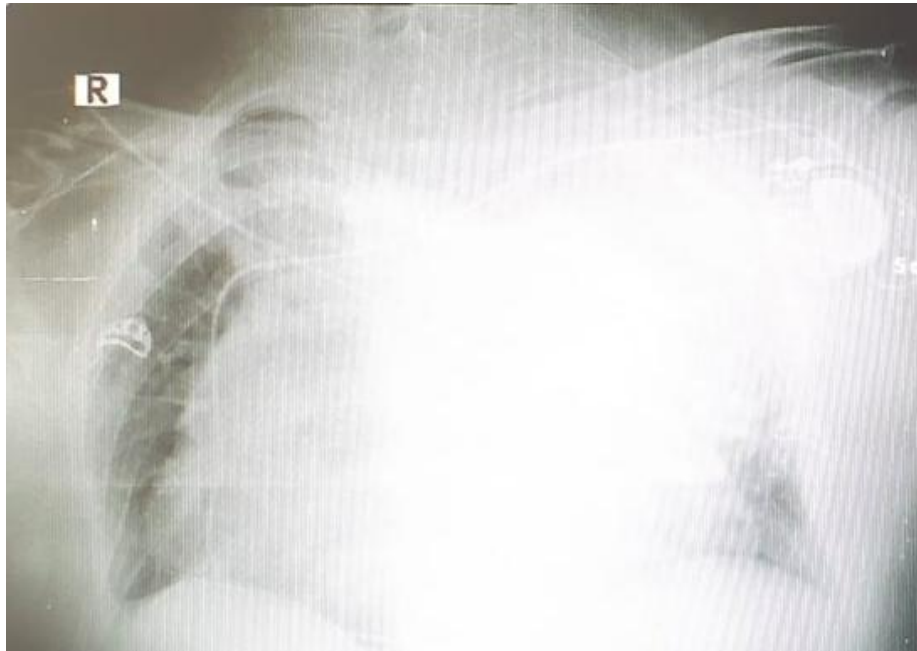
Opacity in the upper and middle regions of the left lung on a chest X-ray.
